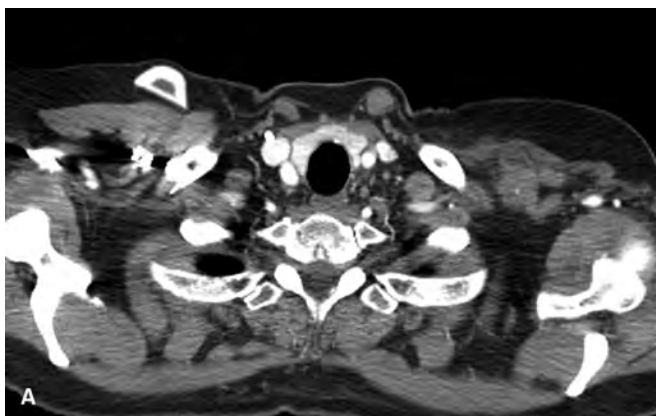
(A) image of right brachial plexus tumor infiltration. (B) Overlay PET/CT scan of right brachial plexus tumor.
